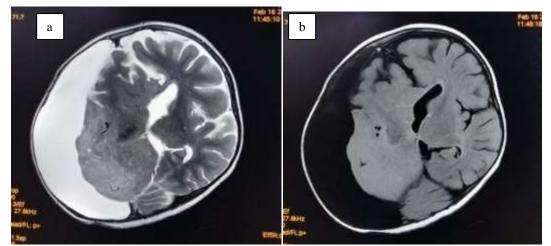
On axial sections of MRI Brain, T2/FLAIR shows right-sided sub-dural collection with pachygyria and lissencephaly of the adjacent brain parenchyma and shifting of the brain to contralateral side.
